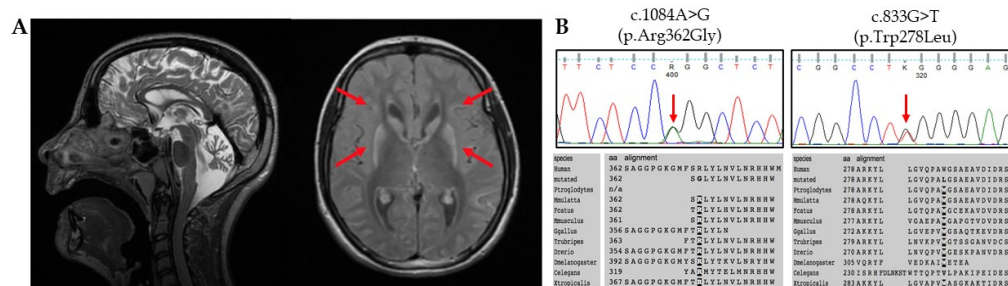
(A) Brain MRI of patient NG2880. Sagittal T2-weighted image (left panel) showing global cerebellar atrophy and thin corpus callosum; axial T1-weighted image (right panel) showing hyperintensity and hypotrophy of caudate nuclei and putamen (red arrows). (B) Electropherograms showing the two identified variants and conservation across species.
